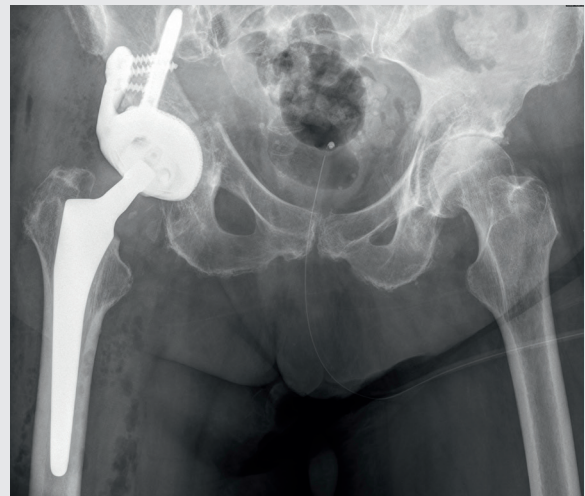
Postoperative radiographic follow-up examination, plain pelvis radiograph A-P
